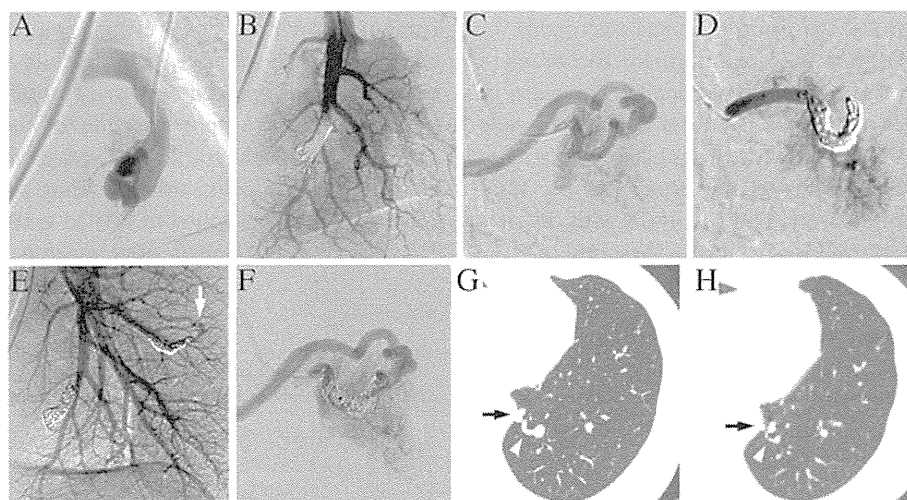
A 62 year-old woman with three PAVMs (Case 6). A. The selective angiogram shows the PAVM in the posterior segment. B. The distal feeding artery was embolized with three 6-4 mm hydrogel microcoils and four additional 3 mm bare platinum microcoils. C. Selective angiogram of the small PAVM in the superior segment shows the tortuosity of the distal feeding artery. D. Because of microcatheter instability, six 4-3 mm 0.014-inch bare detachable microcoils alone were deployed. Post embolization angiogram shows the feeding artery occlusion. E. After two months, the follow-up pulmonary arteriogram was obtained in the second session to treat the PAVM in the right lung (not shown). The PAVM in the posterior segment treated by hydrogel microcoils remained occluded, whereas the smaller PAVM in the superior segment treated by bare microcoils alone shows recanalization (arrow). F. Selective angiogram reveals the recanalization through the coil interstices. Four additional 3 mm bare microcoils were packed proximally to achieve complete occlusion (not shown). G. The baseline non-contrast CT image shows the venous sac (arrow) and the draining vein of the PAVM in the posterior segment (arrowhead). H. The eleven-month follow-up CT shows shrinkage of the venous sac (arrow) and normalization of the draining vein size (arrowhead).
